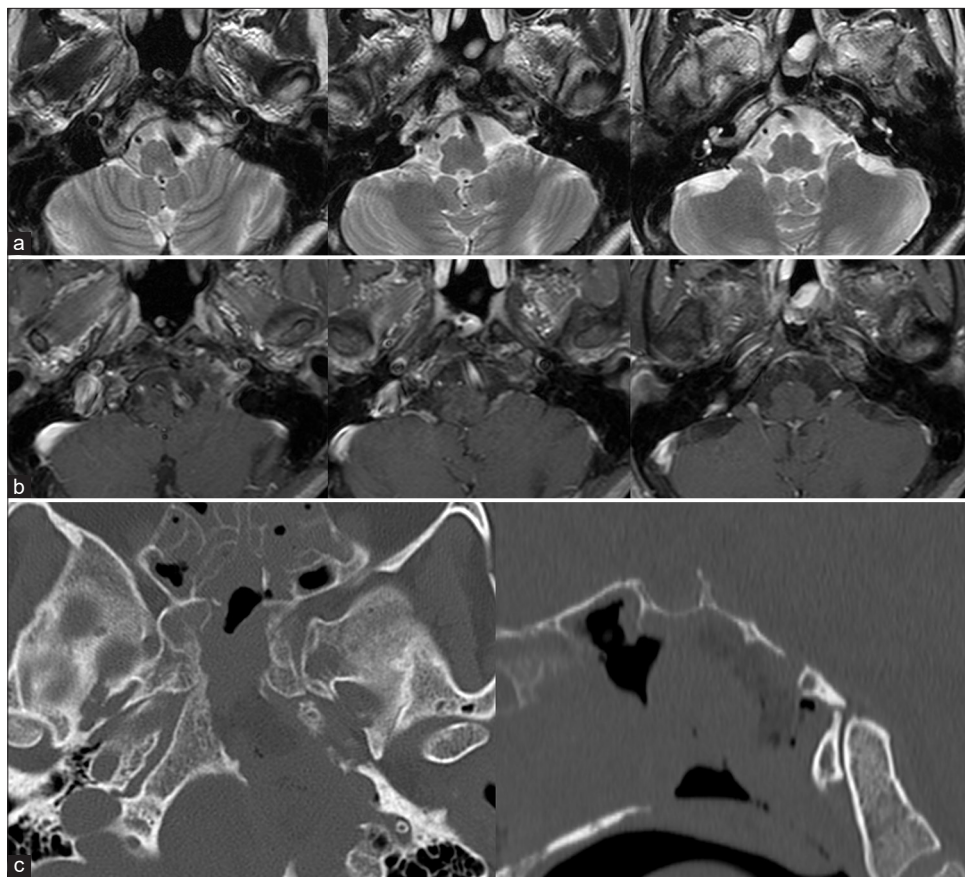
Postoperative head magnetic resonance (a: T2-weighted images and b: gadolinium-enhanced T1-weighted images) and computed tomography images (c: left, axial images; right, sagittal images). (a and b) Cystic and ring-enhanced tumors are completely removed. Brainstem compression by the tumor is also resolved. (c) The access route from the sphenoid sinus to the clivus is observed.
